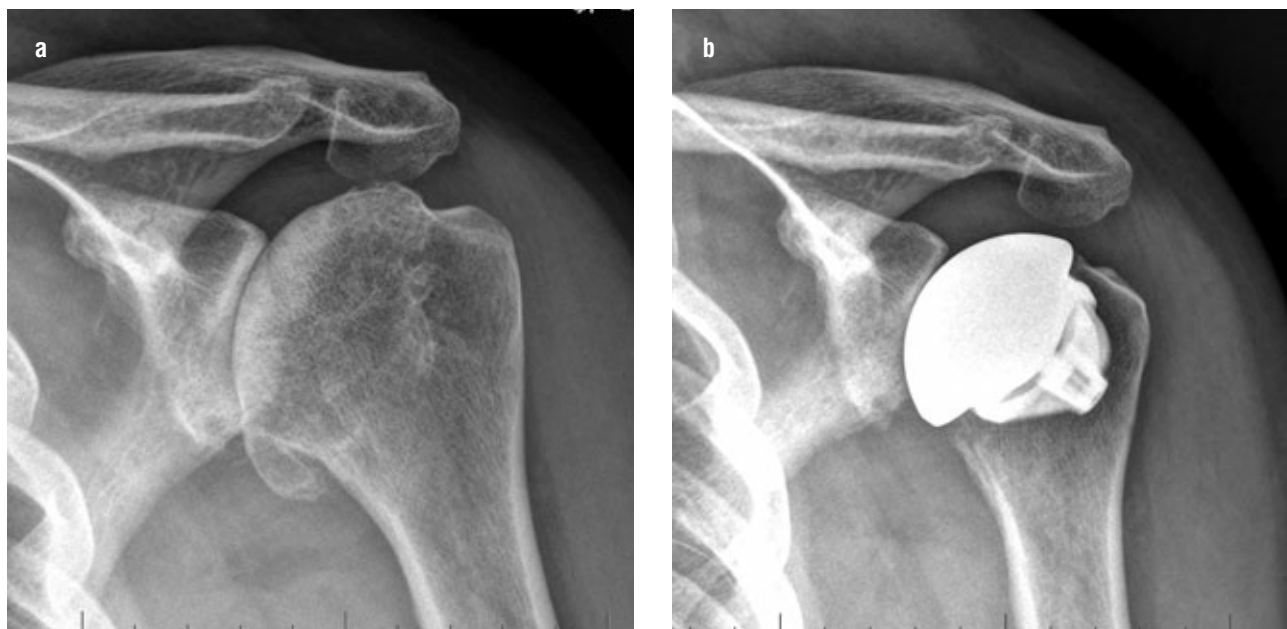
Pre- and postoperative radiographs of one of the patients.
